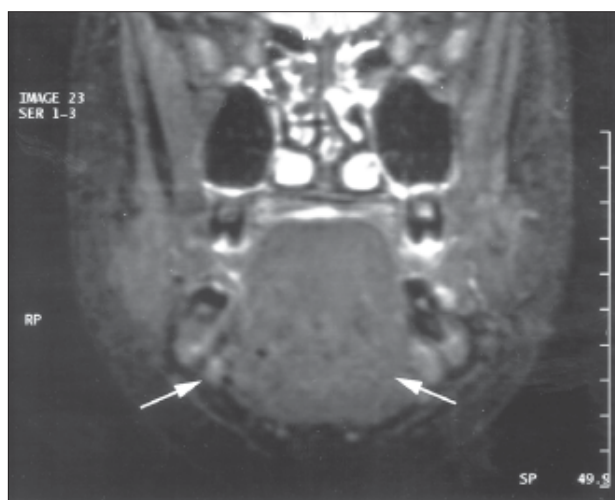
Coronal MRI scan in the region of the first molars. The arrows indicate the sites of the absent submandibular glands.
